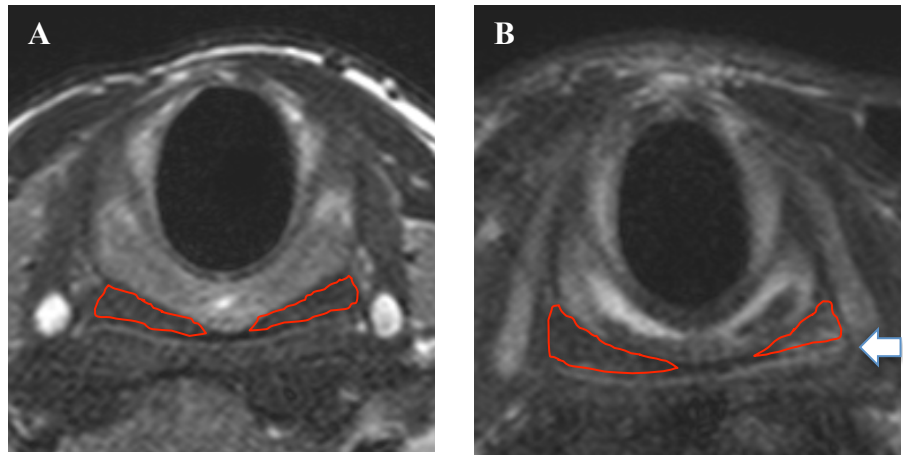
This figure shows T2-MRI of larynx images in axial view showing posterior cricoarytenoid muscles of a: A) healthy volunteer; and B) unilateral vocal fold paralysis patient. The arrow shows left side paralysis in which the bulk is smaller and the signal intensity is higher than the normal side. The region of interests are drawn in redlines.
